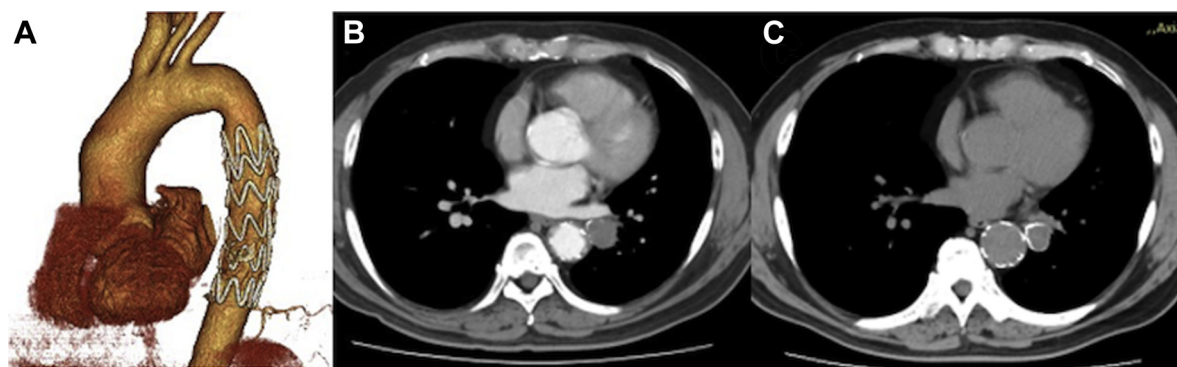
Postoperative computed tomography (CT) at 1 (A and B) and 6 (C) months after surgery reveals a significant shrinkage of the aberrant aneurysm.
